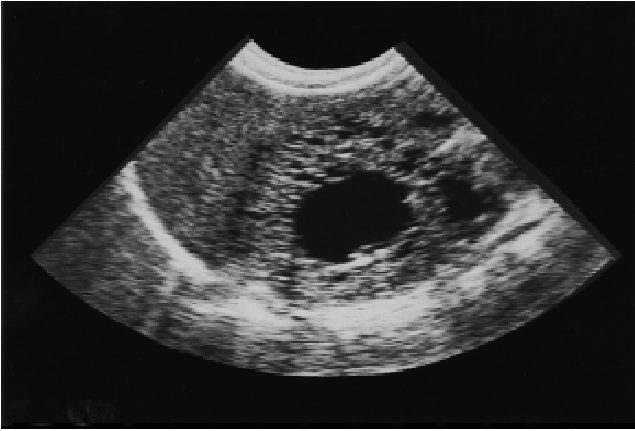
Ultrasound of the left kidney showing multiple septated sonolucent areas.
